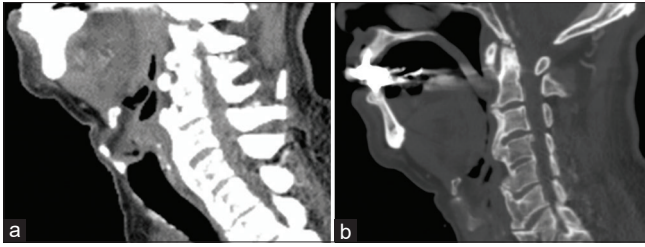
(a) Computed tomography showing the presence of large anterior cervical osteophytes causing ventral displacement of the posterior pharyngeal wall; (b) Radiography of the cervical spine showed extensive ossification of anterior longitudinal ligament
